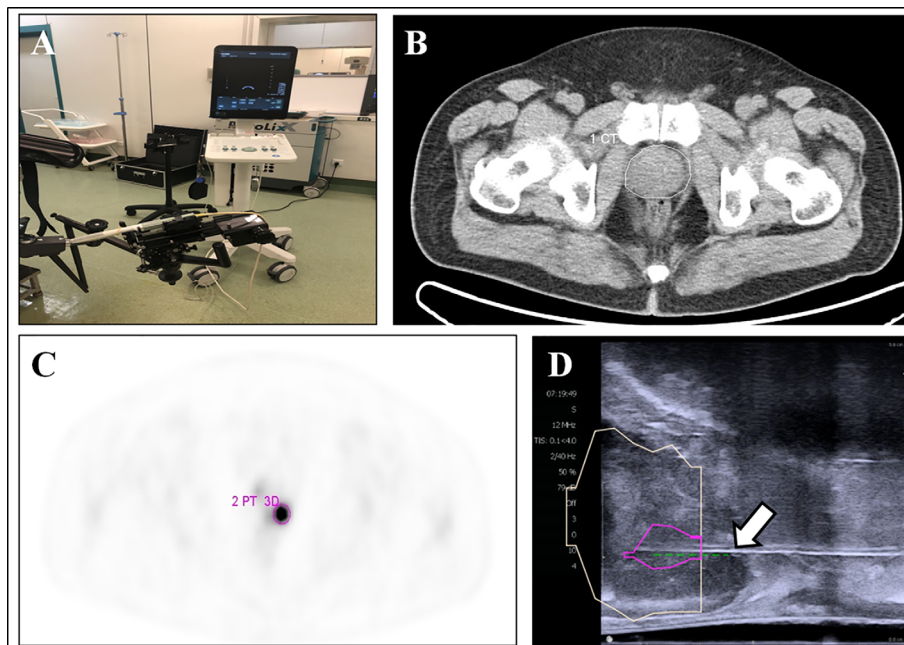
¹⁸F-DCFPyL PET/CT-US or PET/MRI-US fusion targeted prostate biopsy for the intraprostatic PET-positive lesions were performed with the BK Predictive Fusion prostate biopsy system (A). The boundaries of the prostate were delineated on the CT image (B, white circle). The PET-positive lesion was marked as the target for biopsy (C, pink circle). The previous delineated prostate and PET-positive lesion from PET/CT was registered to the prostate volume acquired from the three-dimensional transrectal ultrasonography; the puncture needle (D, arrow) then reached the target biopsy area.
